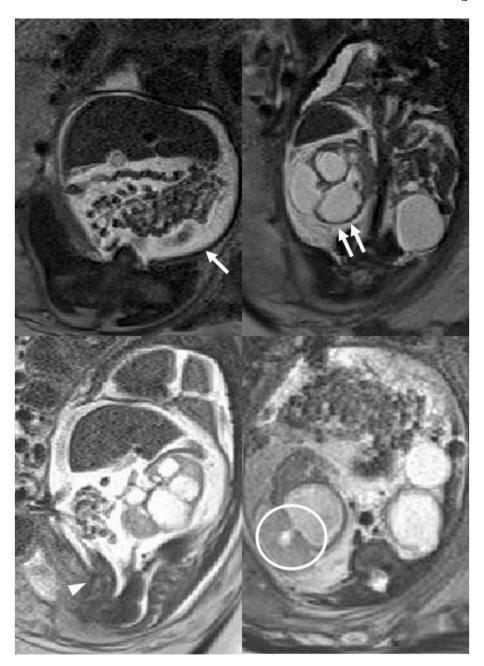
MRI findings (half-Fourier acquisition single-shot turbo spin-echo) at 34 weeks' GA.
